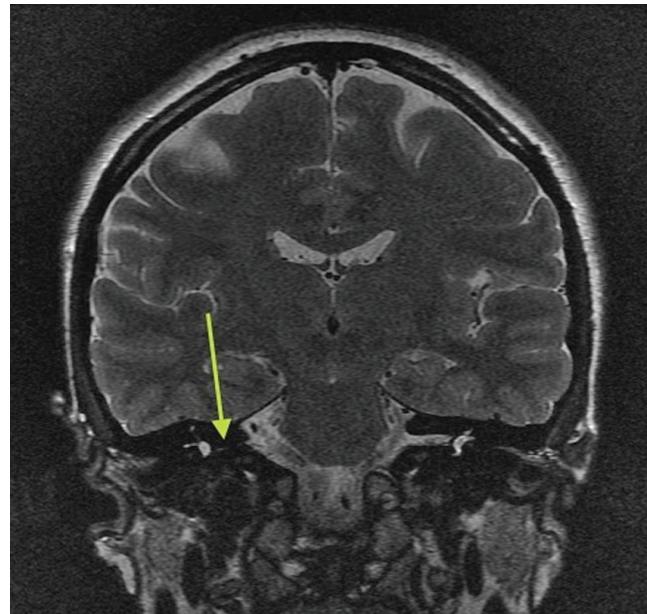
MRI scan no. 1654/11/MR2: cranial nerve VIII on the right visible within the cerebellopontine angle; the nerve is narrower than the contralateral counterpart due to hypoplasia or aplasia or its cochlear components and the superior vestibular nerve; the ampullae, semicircular ducts, and cochlear turns bilaterally unremarkable; cranial nerve VII bilaterally unremarkable.
